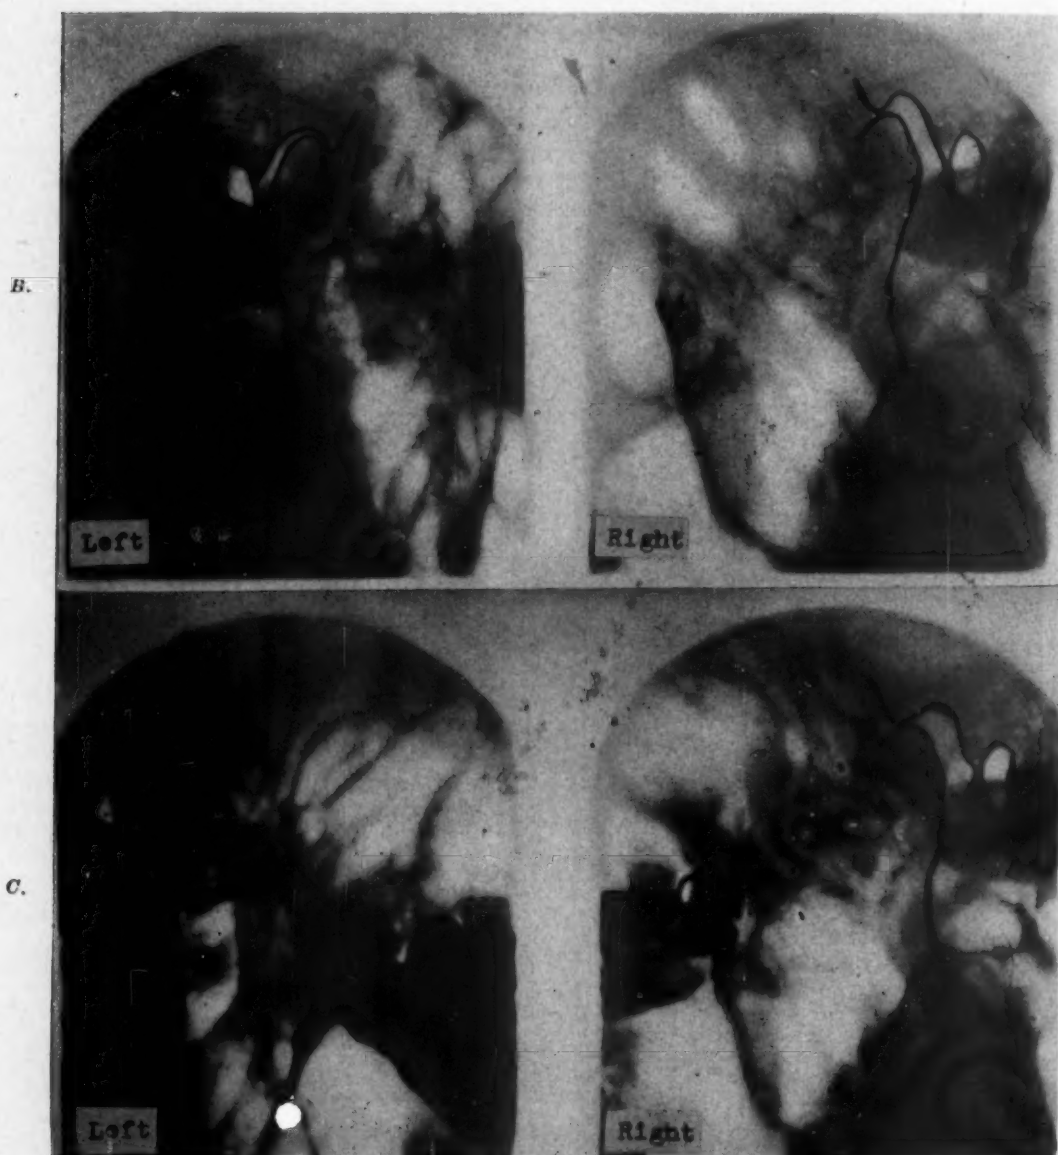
Case 4.—Condyle x-rays of this patient taken the same day, *B*, before and, *C*, after. Patient never experienced any joint discomfort resulting from repositioning his mandible.
